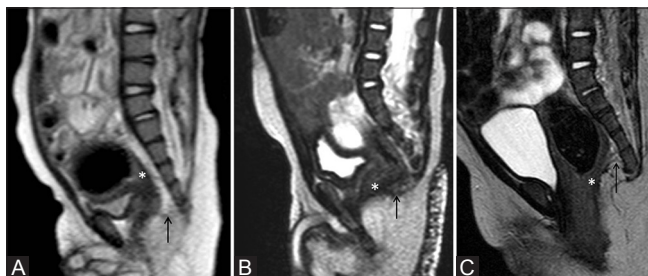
(A-C): Level of rectal pouch (*) as identified by hyperintense mucosa lying above, at or below pelvic floor (arrow) on T2-weighted sagittal image. (A) High type. (B) Intermediate type. (C) Low type. Also note that rectum is opening into the vestibule in (C) (rectovestibular fistula)
